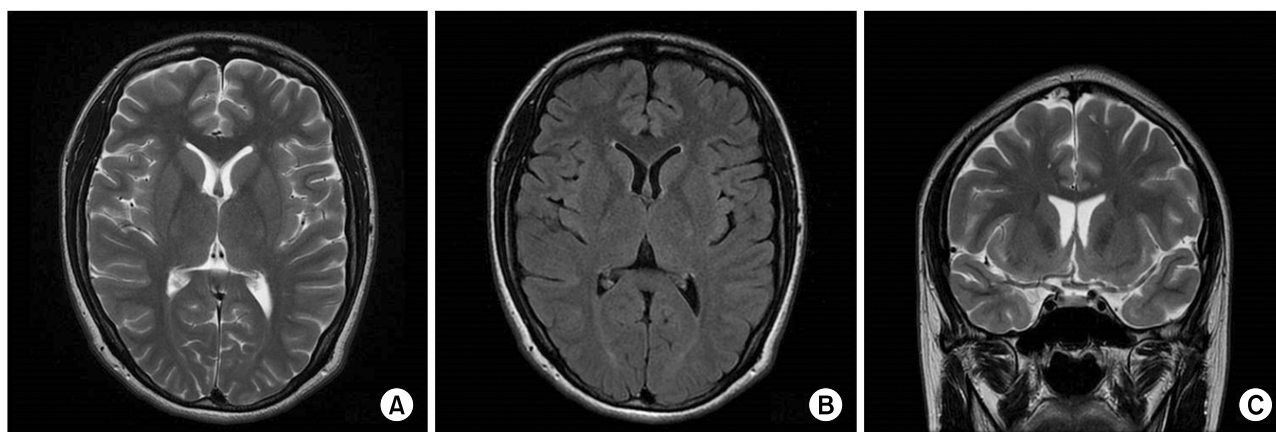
Brain magnetic resonance imaging (MRI). (A) Axial T2-weighted MRI. (B) Axial FLAIR MRI. (C) Coronal T2-weighted MRI.
